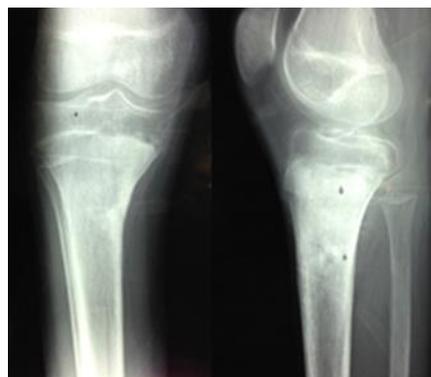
Plain radiograph anteroposterior and lateral view of the knee showing osteoblastic lesion of the proximal tibia.
